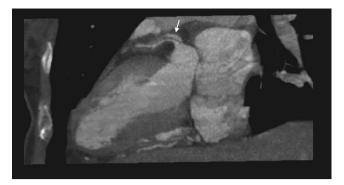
Coronary CT angiogram shows dissection of the leftmainarteryasitbranchesintotheproximal left anterior descending artery (white arrow)
